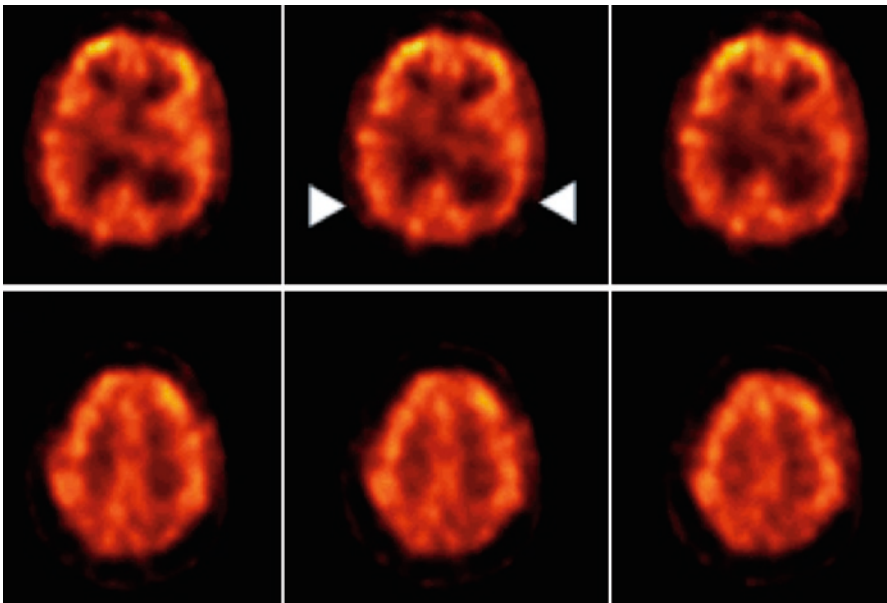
Axial FDG-PET images demonstrate marked hypometabolism of both parietal lobes (*arrowheads*). This is a little more pronounced on the left. Findings are typical of Alzheimer's disease
